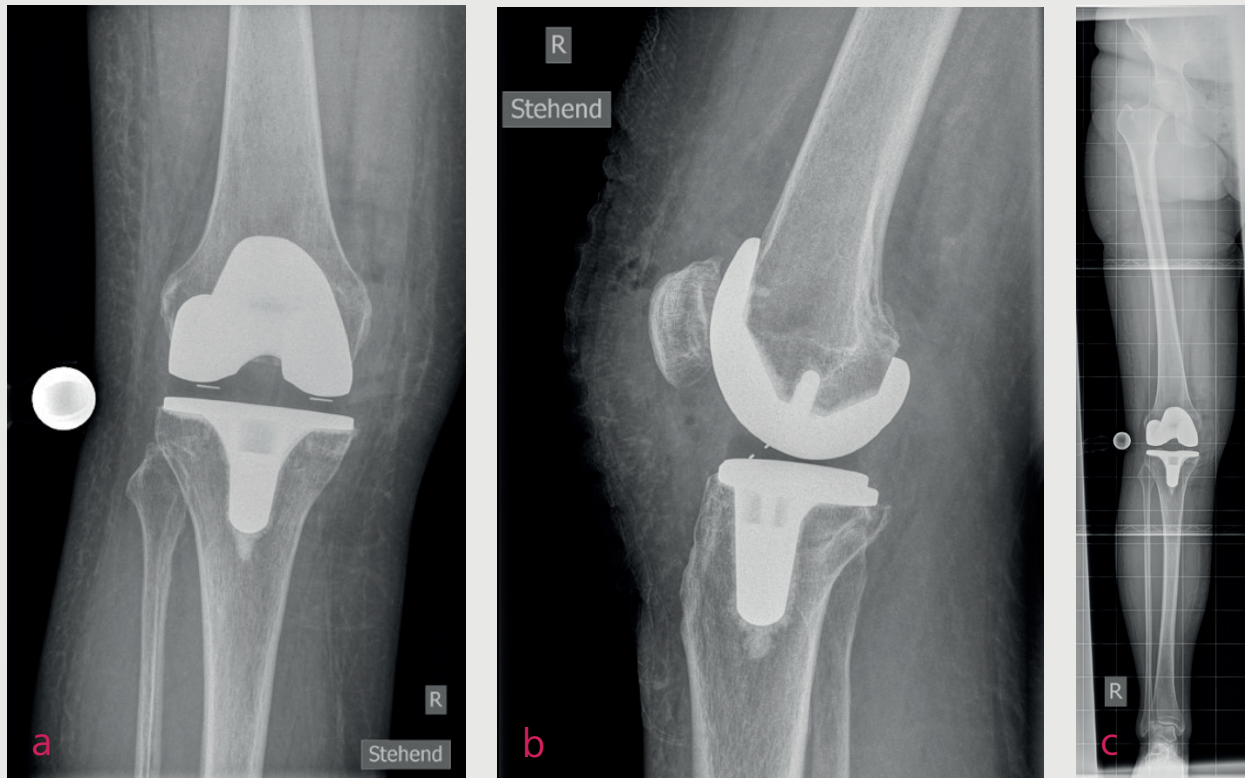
Postoperative radiographs on the right (a) in a.p. projection, (b) in m.l. projection and (c) whole-leg radiograph in a.p. projection, control of the knee axis and implant position
